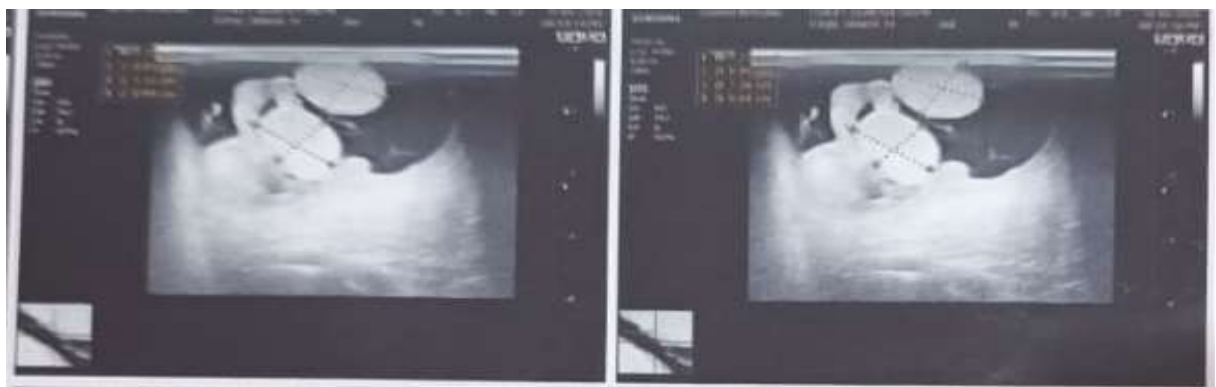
Ultra-sonography (abdomen+ pelvis)
